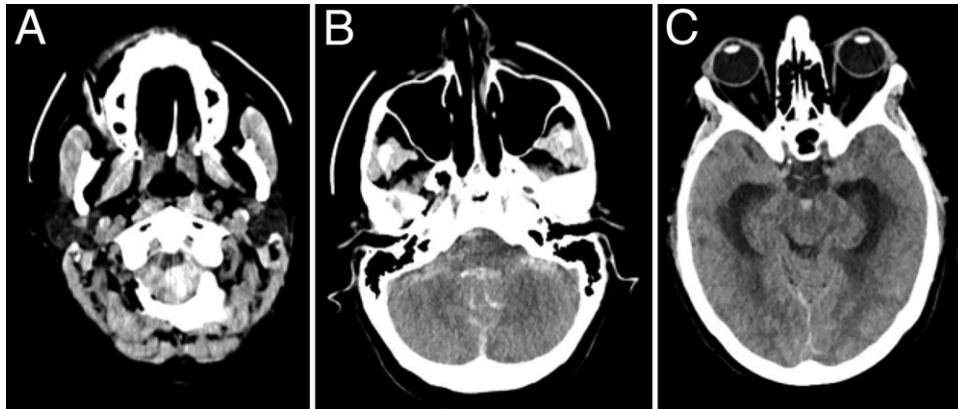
Axial noncontrast CT of the head showing upper cervical subdural hemorrhage (A), posterior fossa subarachnoid hemorrhage (B), intraventricular hemorrhage in the fourth ventricle (B), and hydrocephalus (C).
